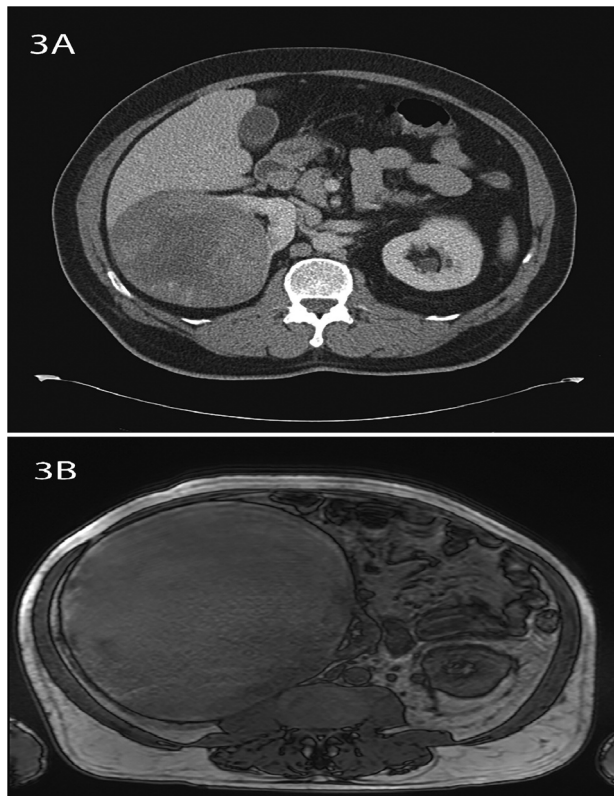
(A) Computerized Tomography Scan performed in July 2013, the mass was 13 cm. (B) Magnetic Resonance Imaging performed in September 2020, this time the mass was 26 cm.
